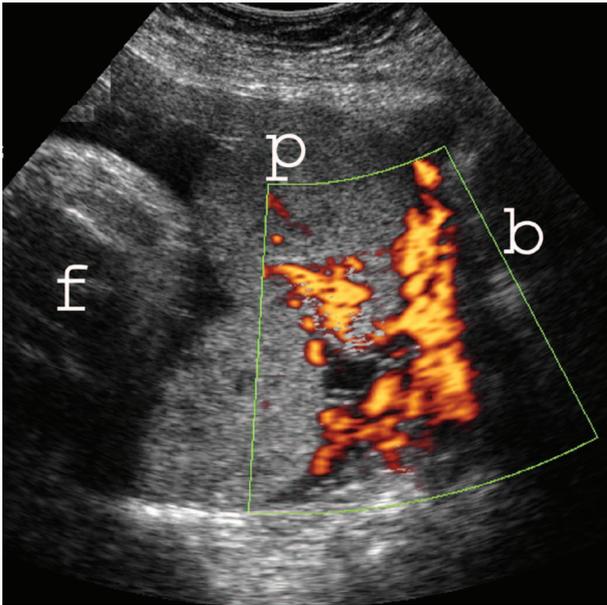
Color Doppler of placenta percreta (same patient as in Fig. 5). Note the vascularity of the bladder wall (*b*). At surgery, the bladder wall was involved. *p*, placenta; *f*, fetus. Oyelese. *Placenta Previa, Accreta, and Vasa Previa*. *Obstet Gynecol* 2006.
